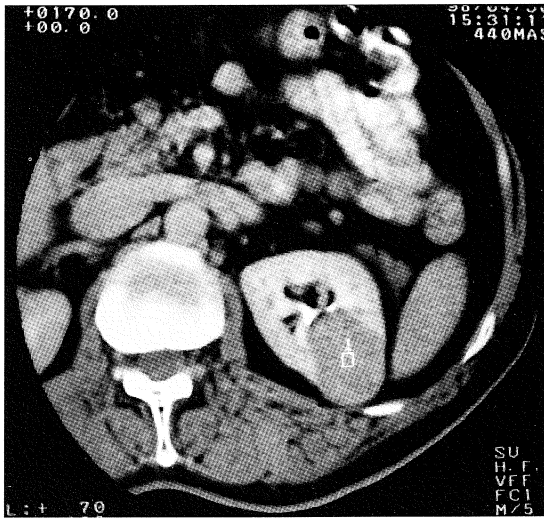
Contrast-enhanced CT scan of the left kidney of a patient with renal cell carcinoma who subsequently underwent partial nephrectomy.
